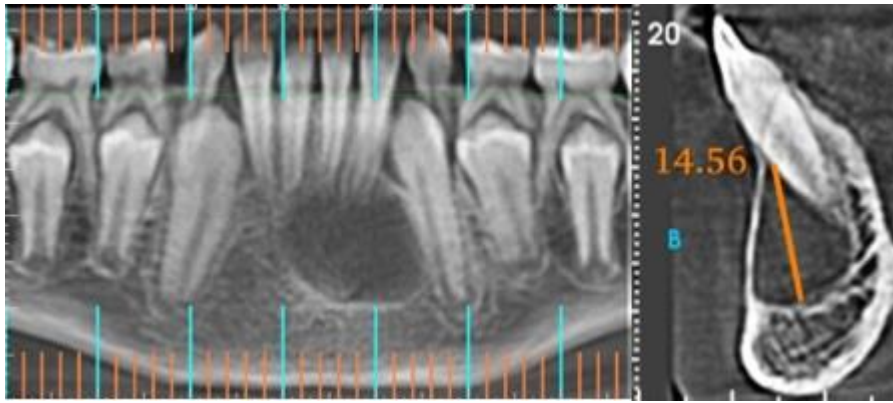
Cone-beam computed tomography revealed a well-defined, circular, radiolucent lesion located between the mandibular incisors, measuring approximately 14.56 mm in diameter.
